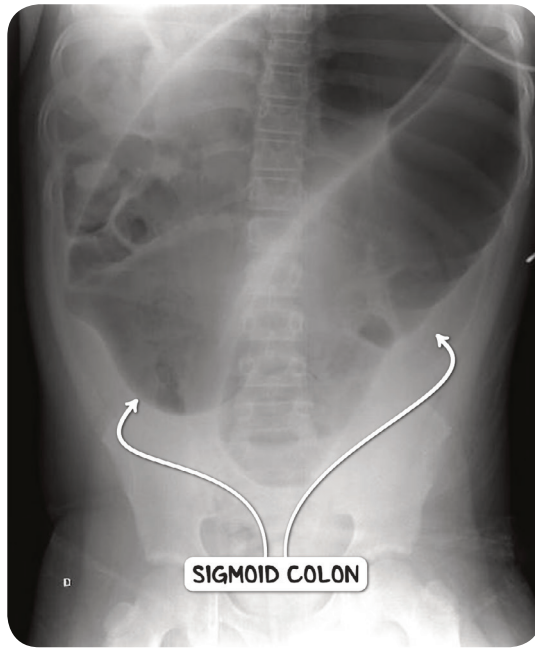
Abdominal radiograph demonstrating a massively dilated sigmoid colon in a case of sigmoid volvulus.
